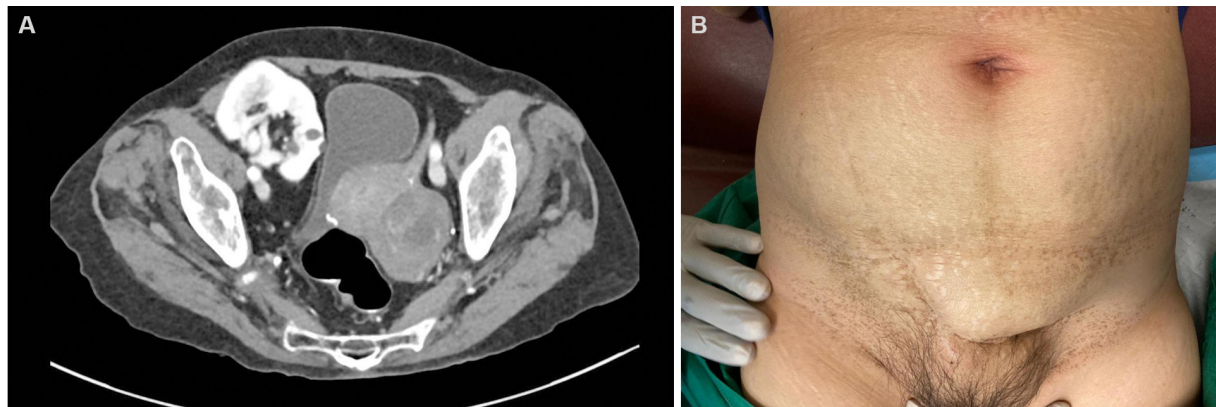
CT Pelvis Axial View showing the left adnexal mass and the transplanted kidney in the right iliac fossa (A). PAbdomen showing suprapubic transverse scar extending to the right iliac fossa (B).
